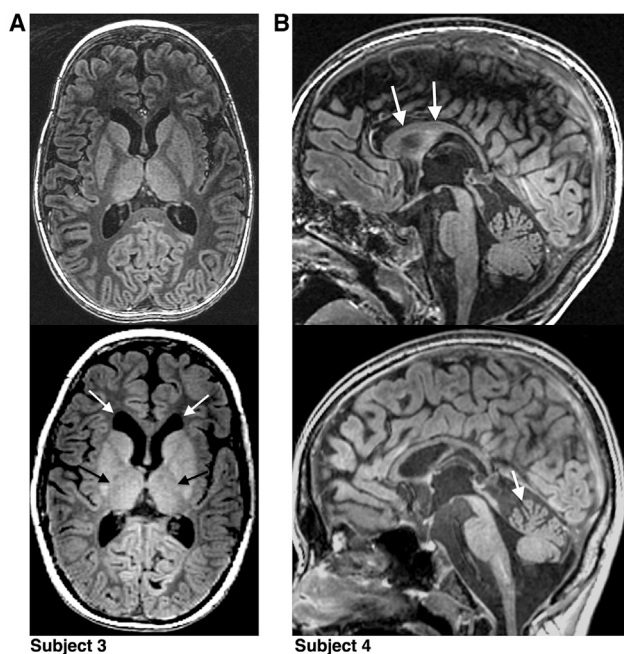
MRI over Study Interval for Subjects 3 and 4
